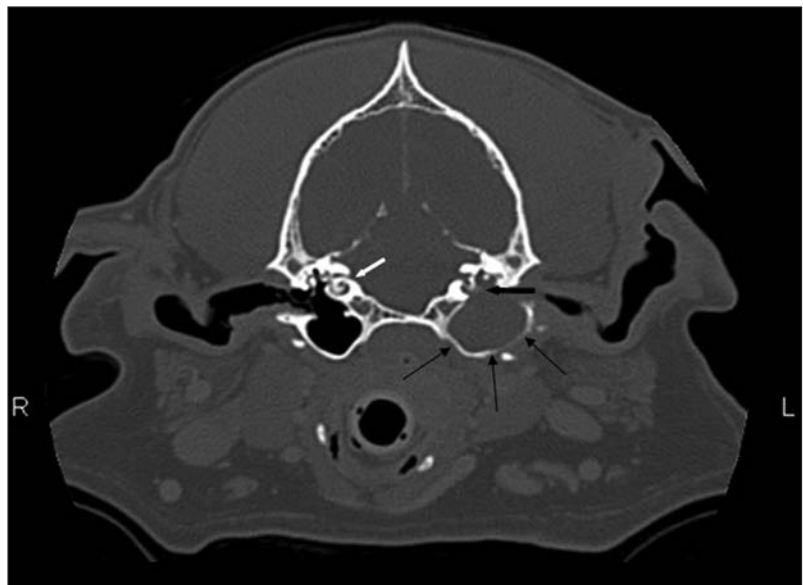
Transverse CT image of the skull at the level of the tympanic cavity displayed in a bone window (slice thickness, 2 mm; window center, 300 Hounsfield units; window width, 1,500 Hounsfield units). There is thickening of the left horizontal ear canal. Notice the left tympanic cavity (thin black arrows). The expanded left tympanic bulla contains material of soft tissue attenuation. Also note the destruction and distortion of the left petrous temporal bone (thick black arrow) and the normal cochlea of the right inner ear (white arrow) compared with the left.
